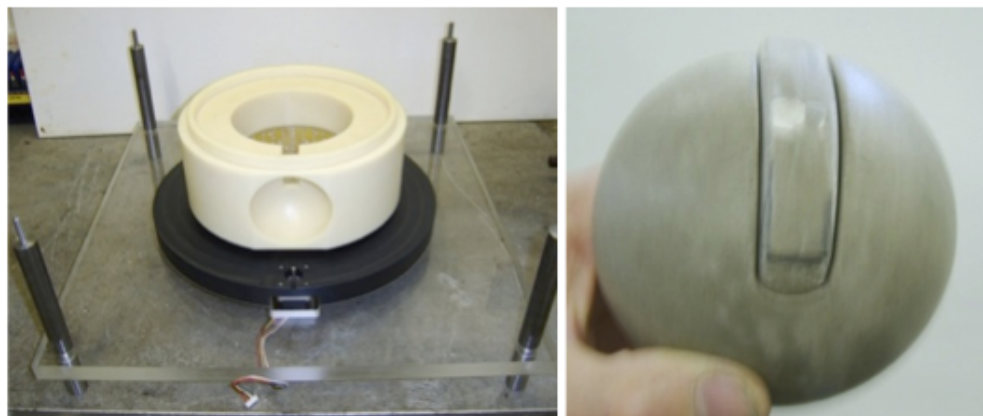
V1 scanner prototype and components (left); hemispherical housing for the ultrasound transducer that fits in the side aperture of V1(right).
